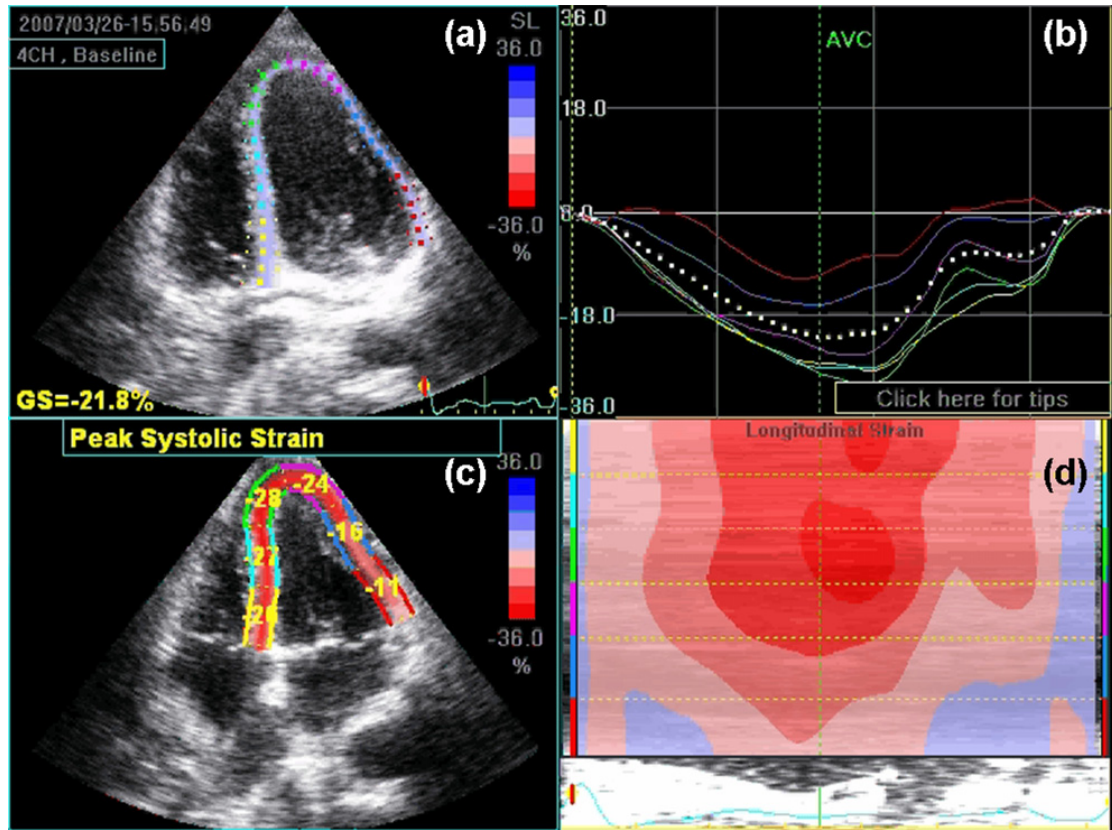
Strain-echocardiography analysis. The contour of the left ventricle is semi-manually defined on a 2D echo image (a). Speckle tracking is used to track basal, middle and apical segments of the lateral wall and septum during a single cardiac cycle, and to compute instantaneous strain for each tracked point (d) and for each segment (b), as well as average global strain (dotted line). The point of end systole (AVC) is used to calculate the peak systolic strain in each segment (c).
